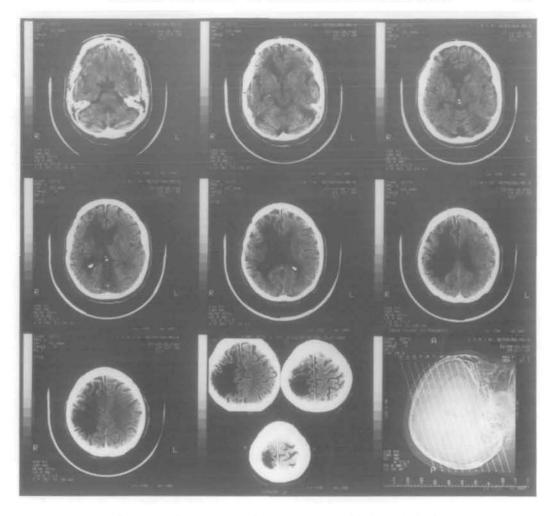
Patient's CT scan showing large right hemispheric lesions (details in text).
